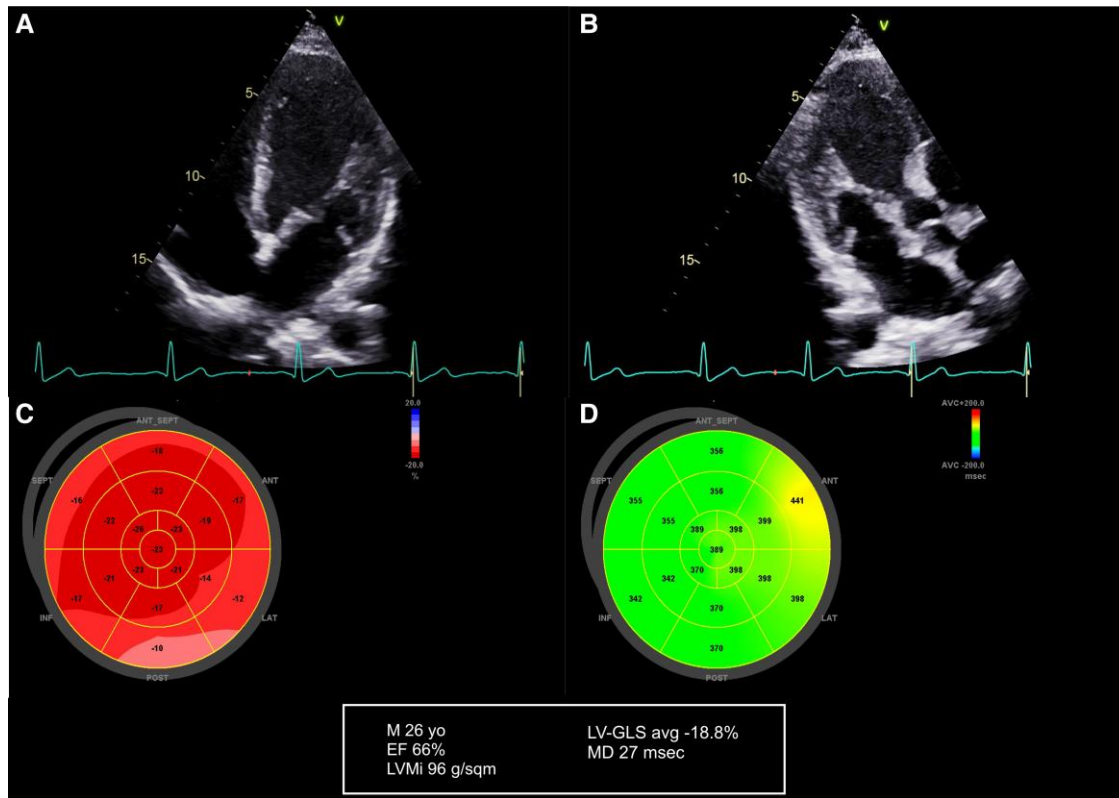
Patient with Anderson–Fabry disease without left ventricular hypertrophy. (A) Apical four-chamber view; (B) apical three-chamber view; (C) global longitudinal strain; (D) mechanical dispersion.
